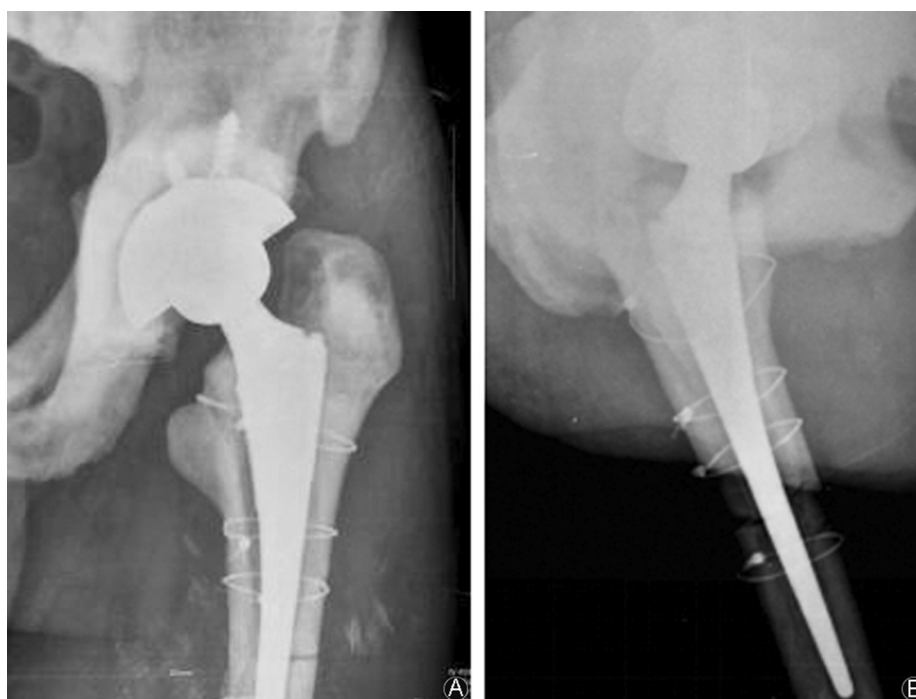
A: AP radiograph of pelvis showing no subsidence of the prosthesis. B: Lateral radiograph of pelvis showing a periprosthetic fracture in distal osteotomy site with slight migration.
